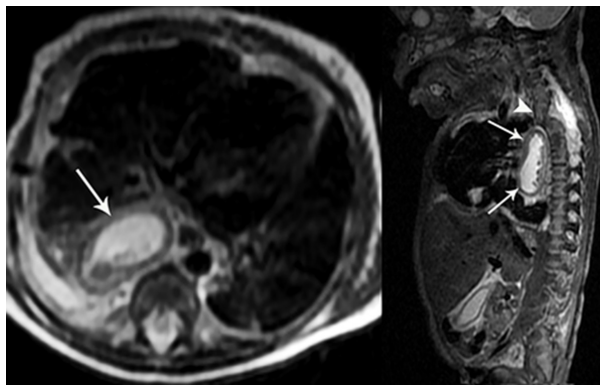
Axial (right) and sagittal (left) T2-weighted magnetic resonance images showing a homogeneous unilocular high signal cystic mass in the right prevertebral region without extension to the spinal canal.
